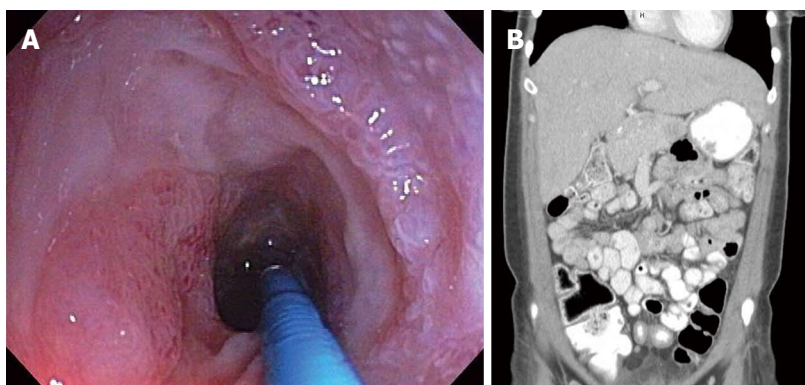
Endoscopic and computed tomography imaging of a terminal ileum stricture in a patient with Crohn's disease. A: Endoscopic imaging of a terminal ileum stricture in a patient with Crohn's disease; B: Computed tomography imaging of a terminal ileum stricture in a patient with Crohn's disease.
